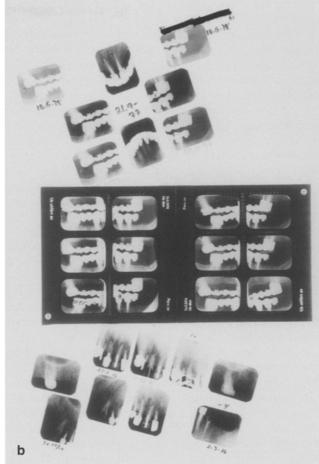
Dental record (1 page, as example) with extensive treatment (a) including several radiographs (b)
